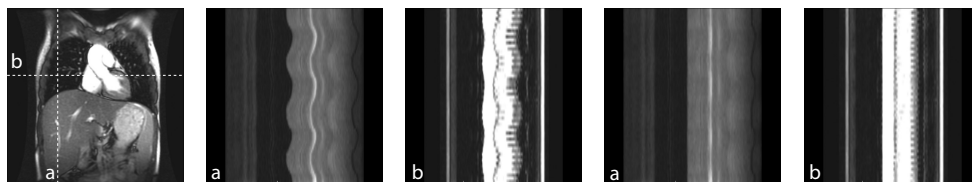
Registration result for a pediatric 2D+t MRI image of the lungs. From left to right: input image (first three), registration result (last two). Image (a) and (b) show the dotted lines in the left image over time.
